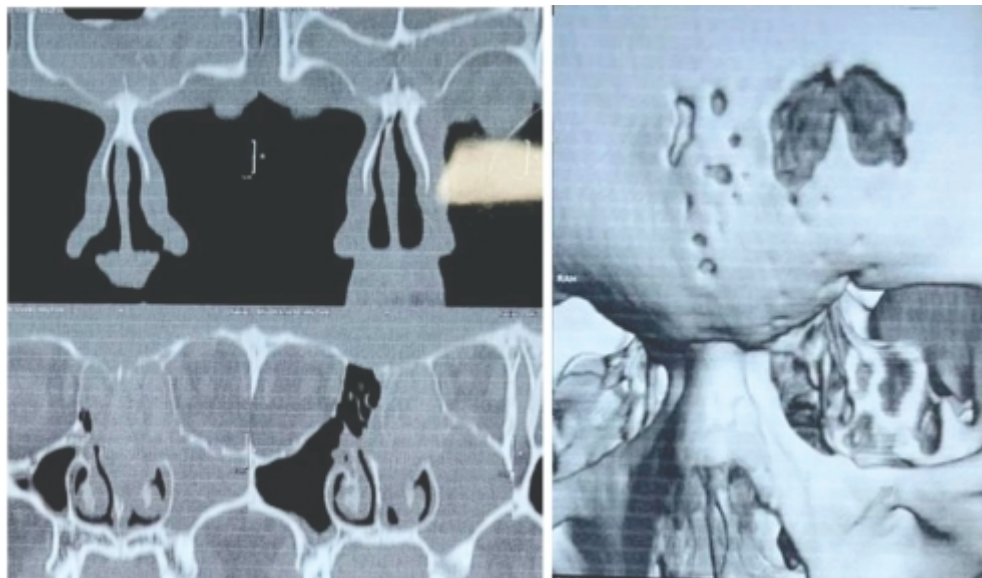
CT images showing frontal, ethmoidal and maxillary sinusitis with hyperdense material within and 3D reconstruction showing eroded frontal outer table
